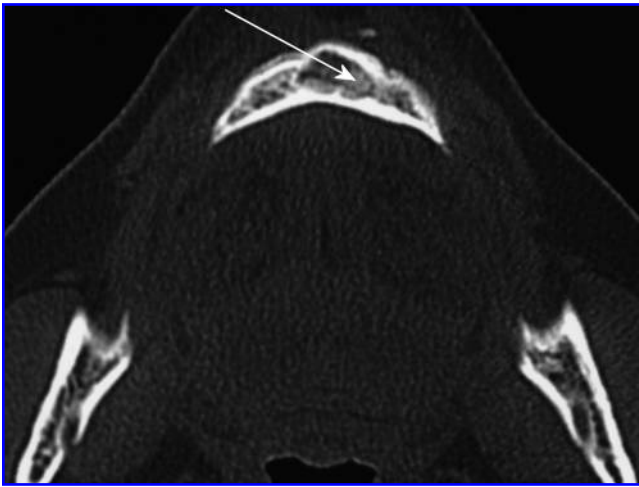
Six-month postoperative computed tomography: former bony defect reconstructed with *de novo* grown bone.
